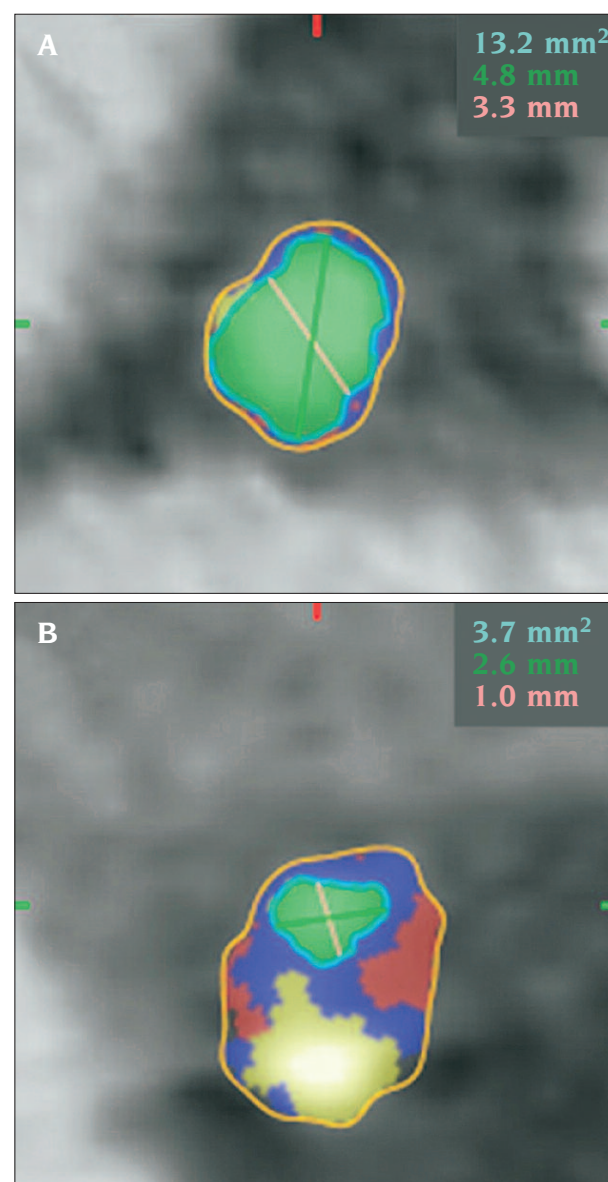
Contrast-enhanced computed tomography coronary angiography for the detection of plaque, minimal lumen area of the plaque, and percent atheroma volume.
